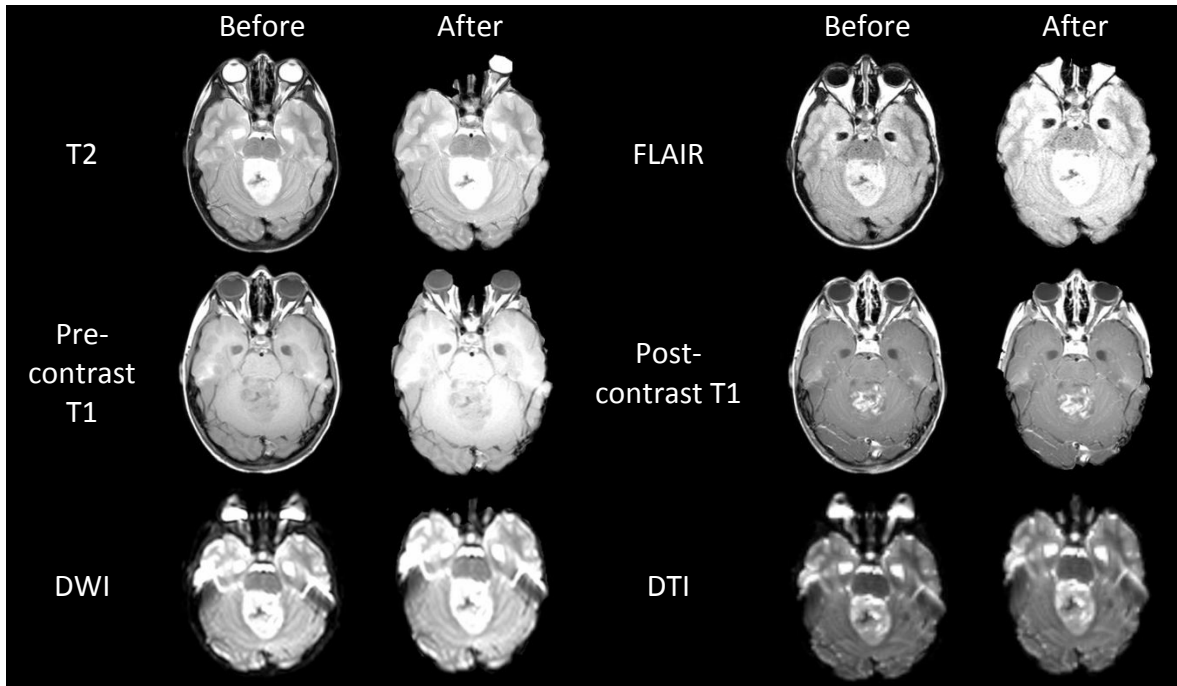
Satisfactory skull stripping outcomes obtained from BET method. Before and after skull stripping of a medulloblastoma based on T2, FLAIR, pre-contrast T1, post-contrast T1, DWI and DTI (case MB783).
